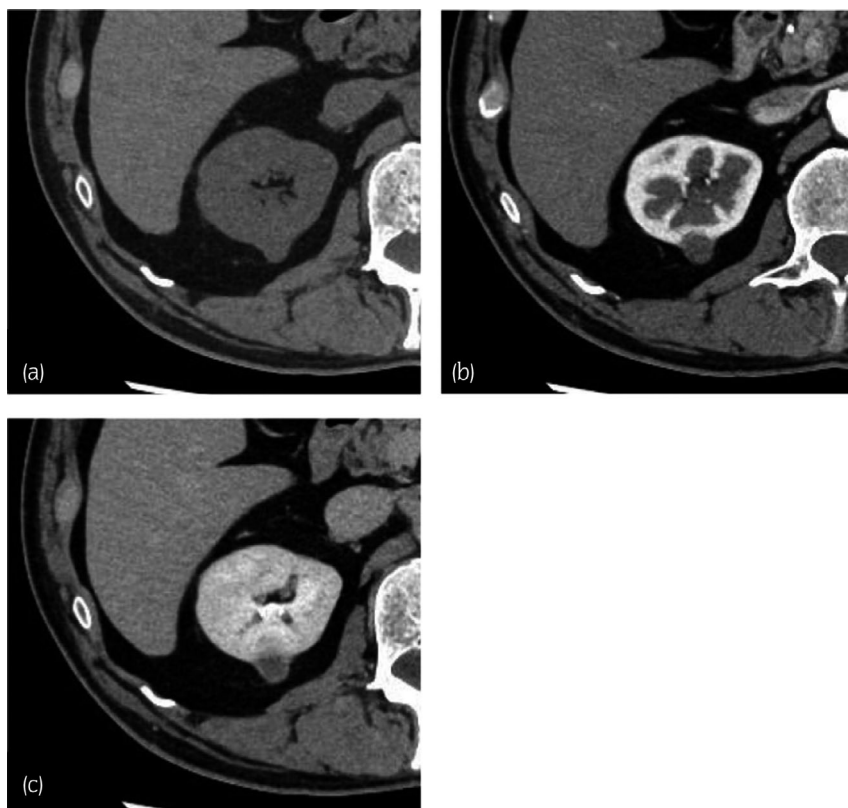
CT images of the right kidney. (a) In the non-contrast phase, it is isodense with the renal parenchyma. (b) Corticomedullary phase and (c) excretory phase show that gradual and weak enhancing effects are suspected in the periphery of the tumor.
